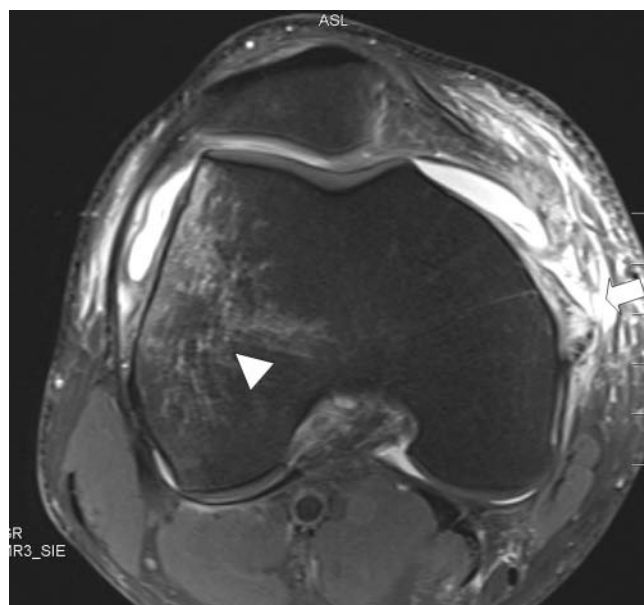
A transverse T2-weighted fast spin-echo MRI of the knee obtained at the level of the medial patellofemoral ligament femoral insertion in a 21-year-old male patient 2 days after a primary traumatic lateral dislocation of the patella. Arrow indicates complete disruption of the medial patellofemoral ligament at its midsubstance. The arrowhead marks a large bone contusion of the lateral femoral condyle.
